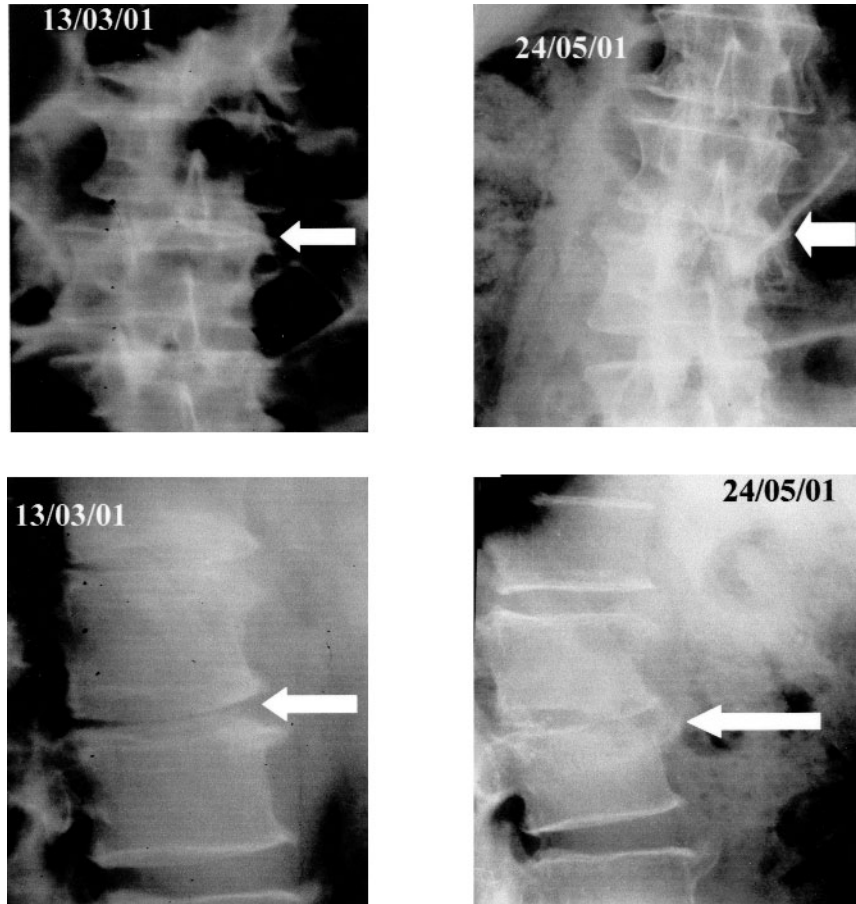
Plain radiographs show progressive damage of the disc space at L2/L3 level during the course of the infection. Destruction of the superior endplate of L3 vertebra and the inferior endplate of L2 vertebra and increased scoliosis developed during the course of the infection.
